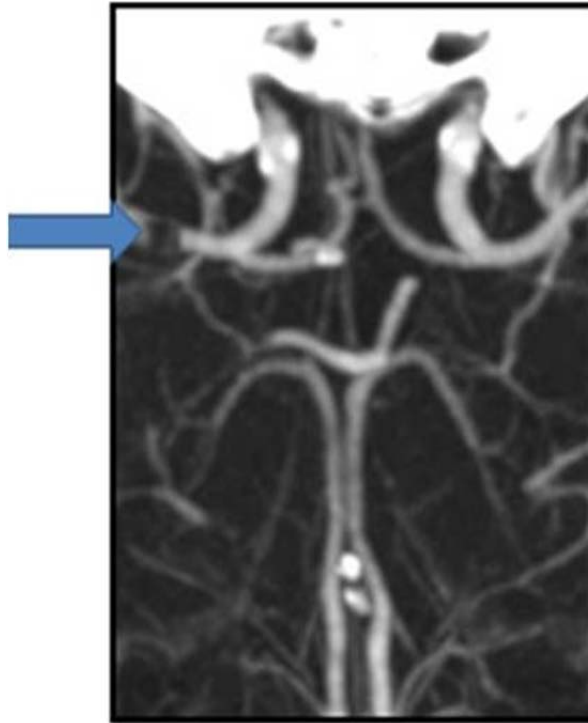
CTA demonstrating right MCA occlusion.
